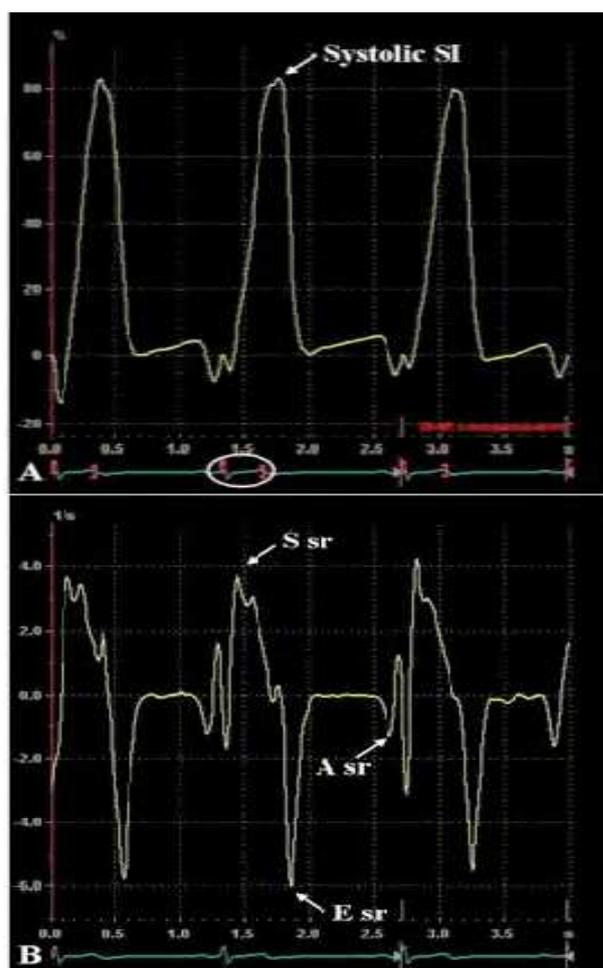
Colour tissue Doppler images of the left atrium.
